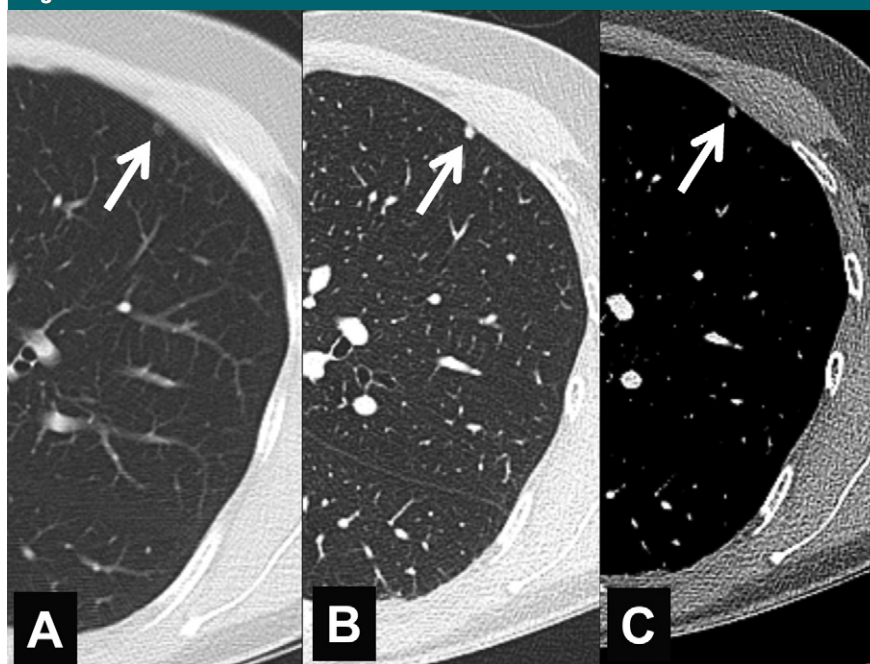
Use of thick versus thin sections for accurate characterization of a 5-mm subsolid nodule (arrow) in lung periphery. *A*, CT scan obtained with 5-mm-thick sections through left upper lobe shows a small apparently pure GGN in lung periphery. *B*, *C*, CT scans obtained with 1-mm-thick sections at same level reconstructed from original volume acquisition images with lung (*B*) and soft-tissue (*C*) windows show that nodule is actually a solid lesion, likely a calcified granuloma.
